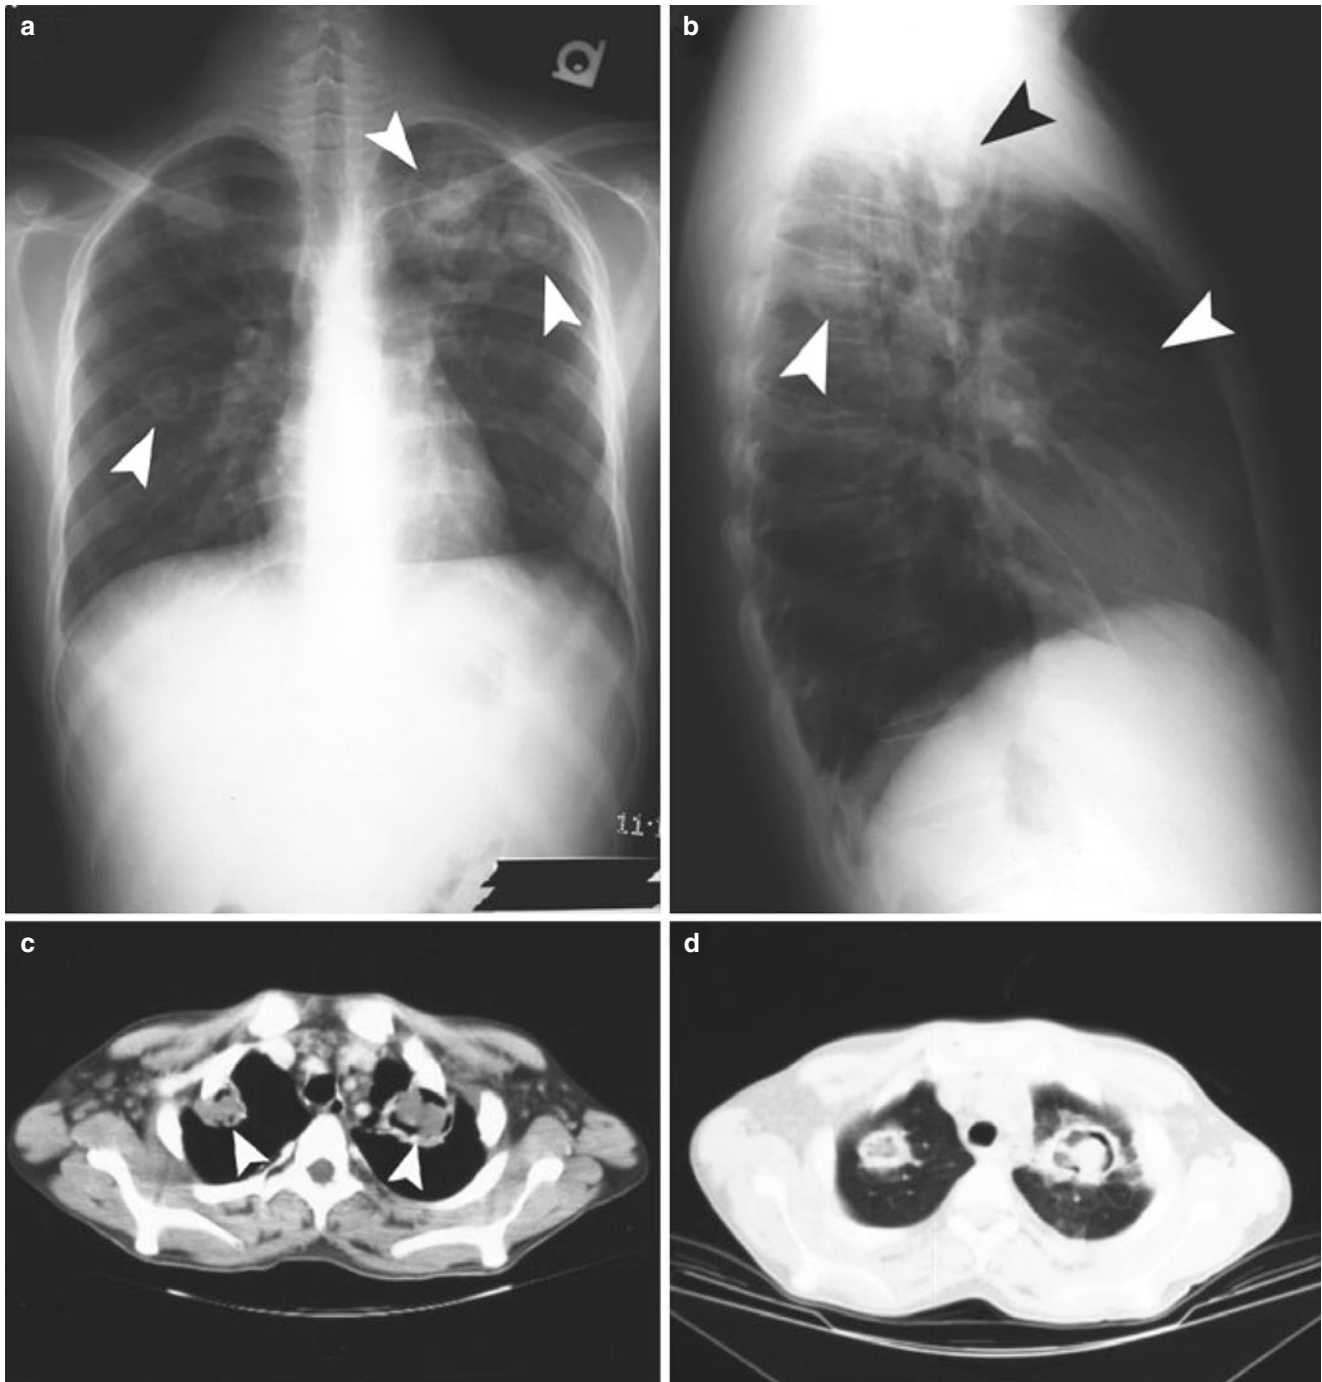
Mucormycosis with fungus balls in a 14-year-old boy on chemotherapy for acute lymphoblastic leukemia. (a, b) Frontal and lateral radiographs show multiple bilateral upper lobe cysts (arrowheads) filled with soft tissue attenuation masses. (c, d) Enhanced axial soft
